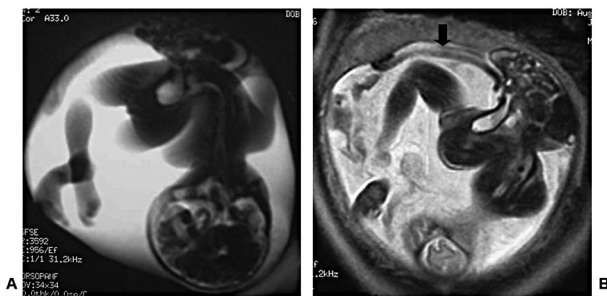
T2-weighted images obtained by single-shot, fast-spin echo sequences. (A) Most of the viscera lie outside the abdomen. Spinal deformity is apparent. There are no significant abnormalities in the limbs and brain. (B) The umbilical cord can be identified but is very short (arrow).
